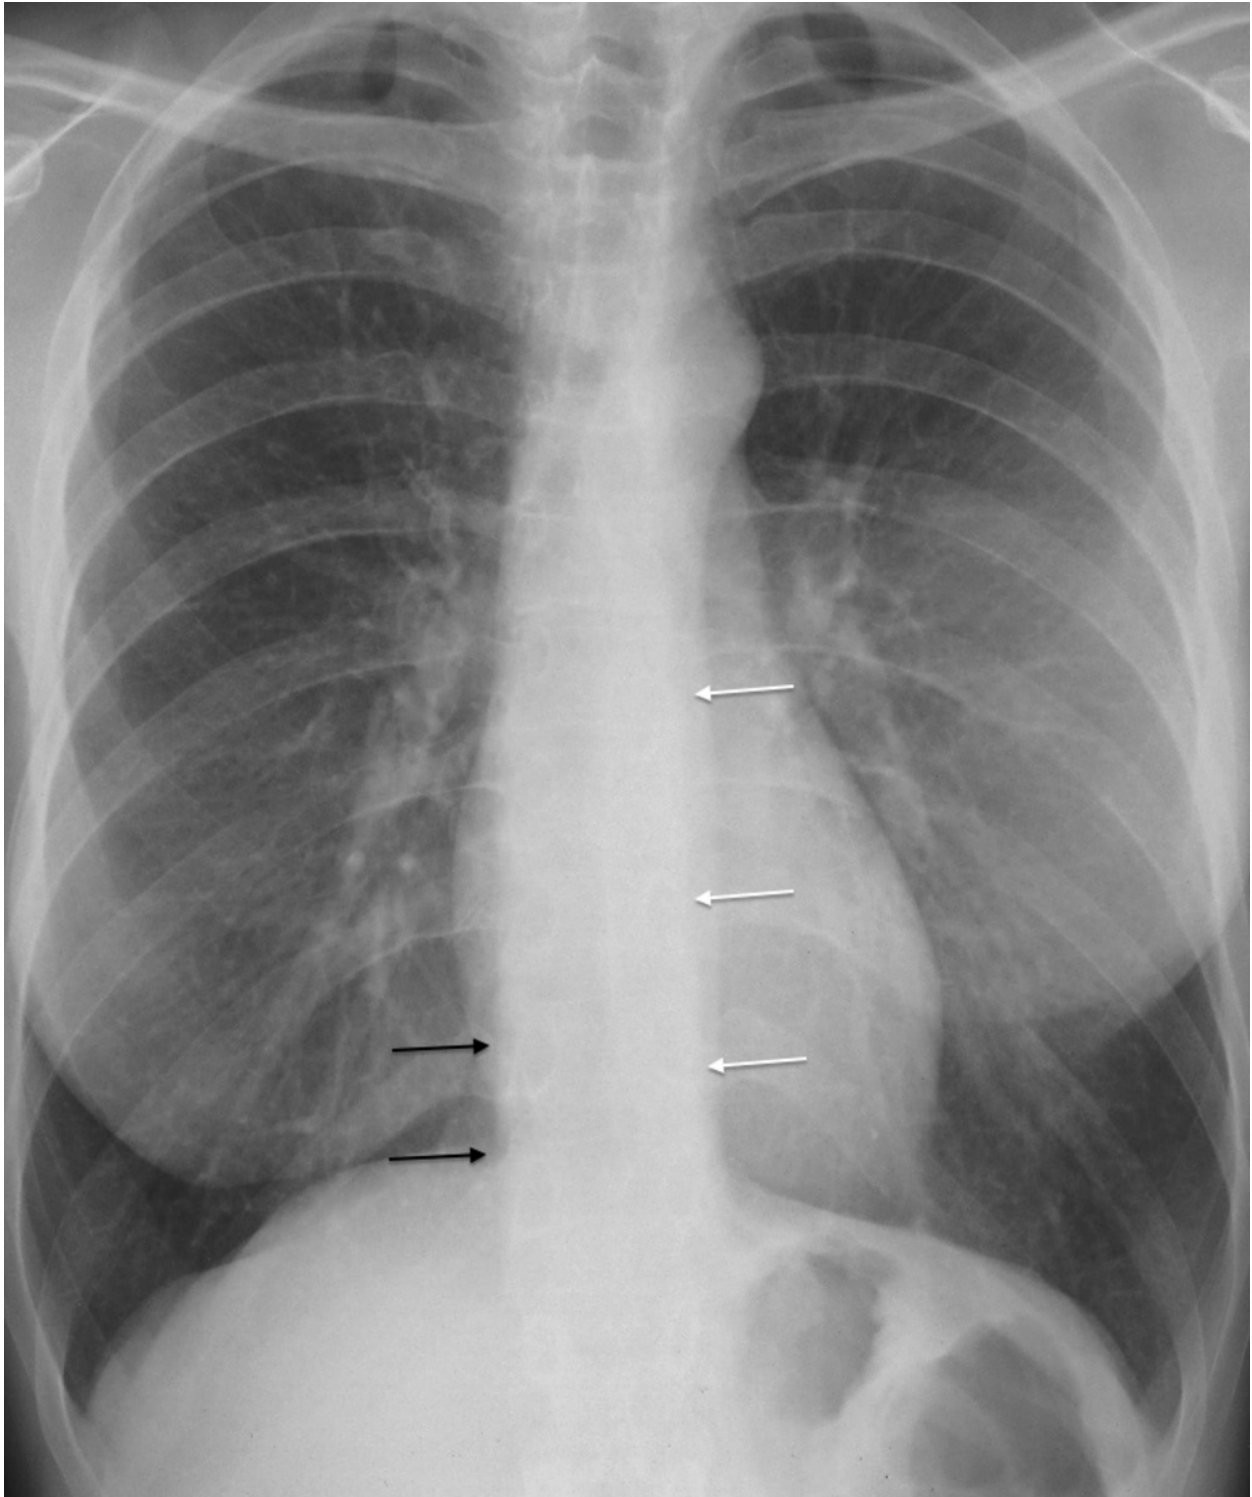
Chest radiograph. Distortion of the paraortic line in a case of aortic dissection.
